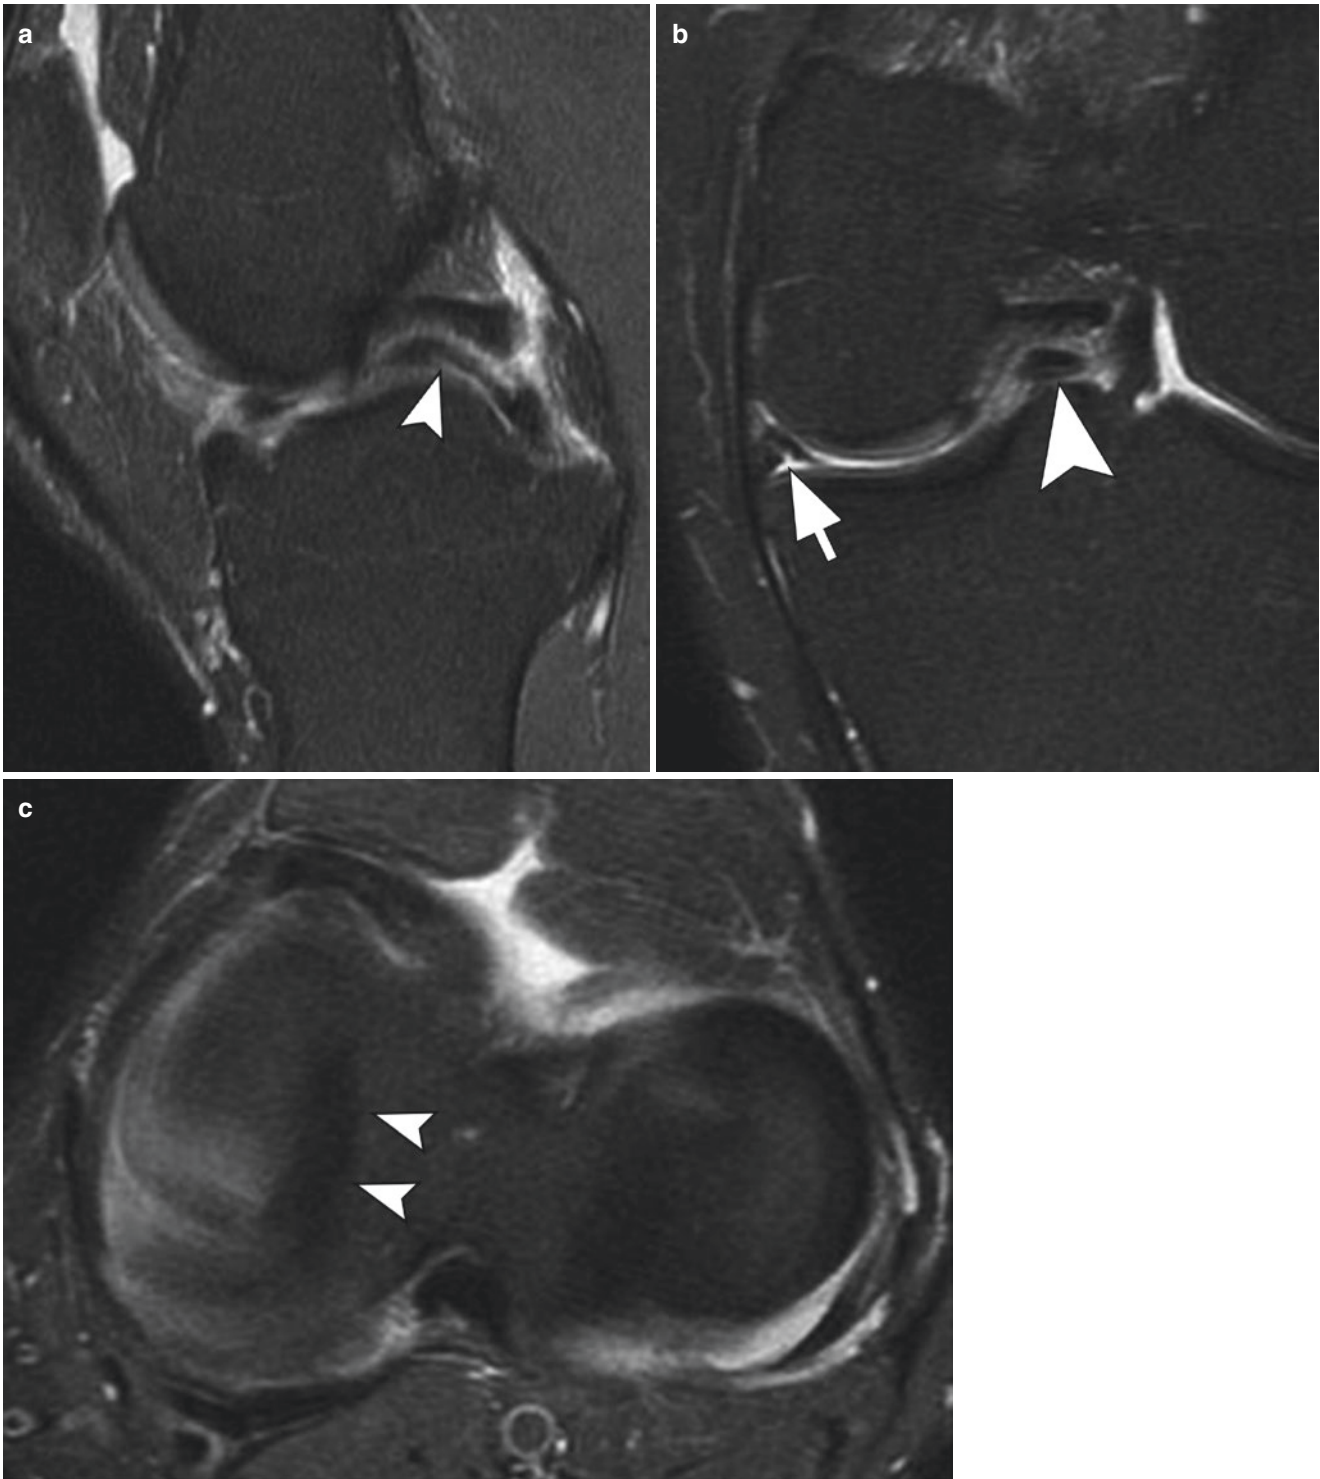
Bucket handle tear. (a) Sagittal; (b) coronal; and (c) axial T2-weighted images of the knee with fat suppression. A complete longitudinal tear of the medial meniscus (arrow) with a displaced meniscal
